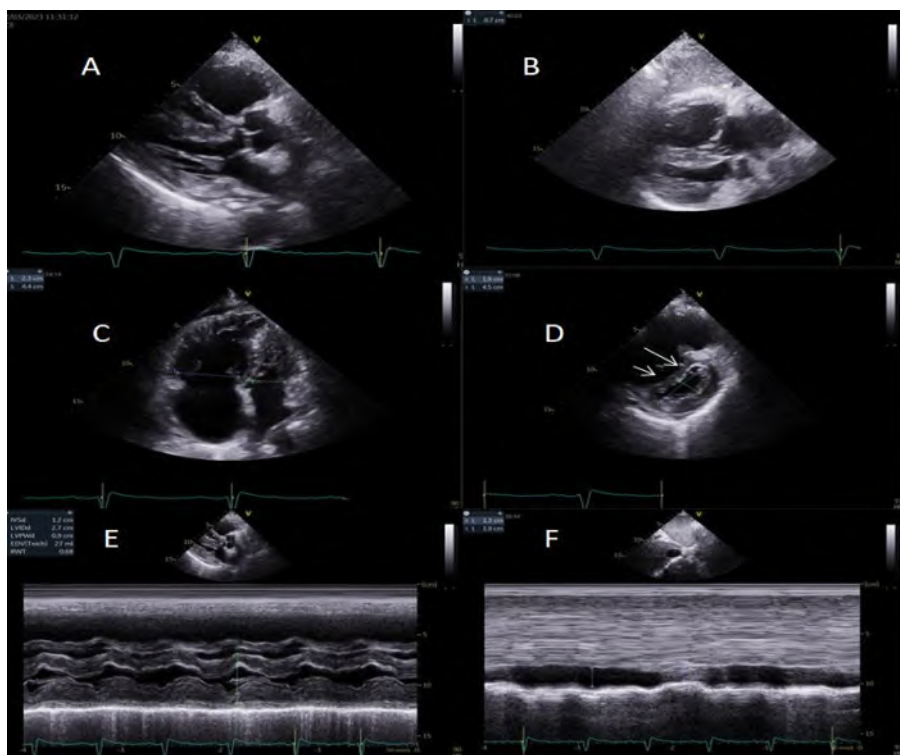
Two-dimensional transthoracic echocardiography in patient with CTEPH (A) PLAX – small LV and large RV with hypertrophy of the RV structures and RV wall; (B) Sub-costal view – RV hypertrophy (7 mm); (C) Four-chamber view - RV/LV ratio bigger than 1; (D) Short axis of the left ventricle on the papillary level -D-shape of the LV, eccentricity index bigger than 1; (E) M-mode of the LV – small LV end-diastolic dimension due to RV overload; (F). Sub-costal view – dilated vena cava inferior, with non-collapsibility of more than 50%.
